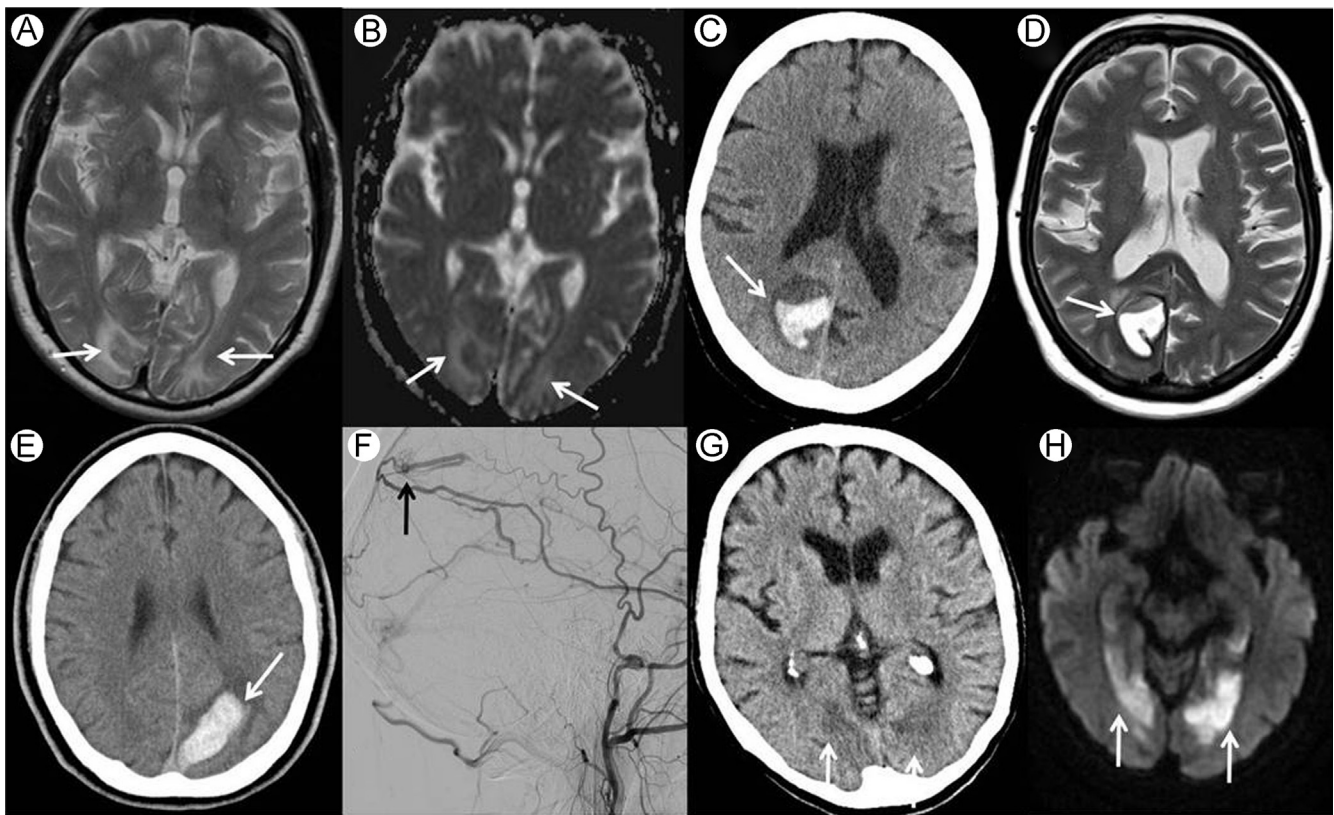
Occipital lobe lesions. (A) Axial T2 and (B) ADC map in a patient with posterior reversible encephalopathy syndrome (PRES) showing bilateral occipital subcortical white matter T2 hyperintensity and increased diffusivity (arrows). (C) Axial CT and axial T2-weighted image of a hemorrhagic right occipital infarct (arrows, C and D). Note that, although swollen, the boundary of the PCA territory is respected. (E) Axial CT of a 34-year-old patient with left occipital hemorrhage secondary to a dural AV fistula (arrow). Note the lesion crosses the PCA territory boundary. (F) External carotid artery injection catheter angiogram in the same patient demonstrating middle meningeal supply of the fistula (arrow). (G) Axial CT and (H) DWI demonstrating bilateral posteromedial temporo-occipital infarcts (low attenuation on CT, arrows, G and showing diffusion restriction, arrows, H) in a patient presenting with prosopagnosia due to bilateral infarction of the fusiform face area. ADC, apparent diffusion coefficient; AV, arteriovenous; CT, computed tomography; DWI, diffusion-weighted imaging.
